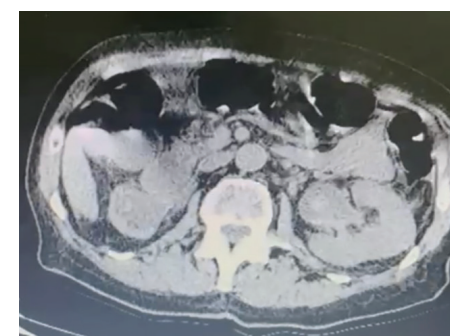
CT axial cut with heterogeneous content in left renal pelvis
